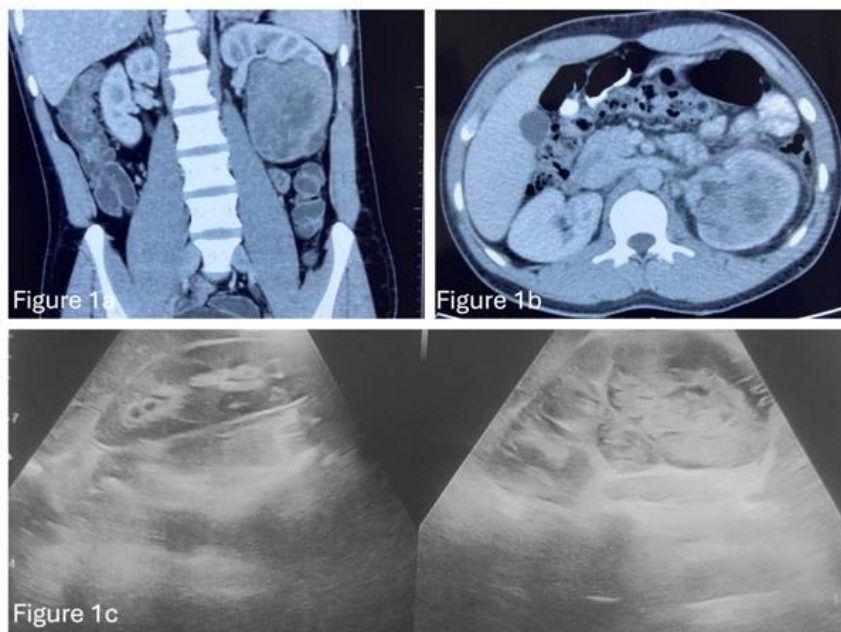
1b (CT Scan) and 1c (ultrasound): shows large solid heterogeneously enhancing mass in mid and lower pole of left kidney.
